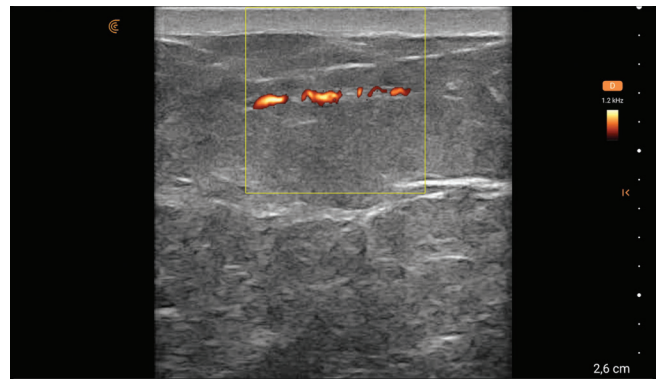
Visualization of the superior perforator using a high-frequency ultrasound device (Clarius L20, Clarius Mobile Health, Canada)
